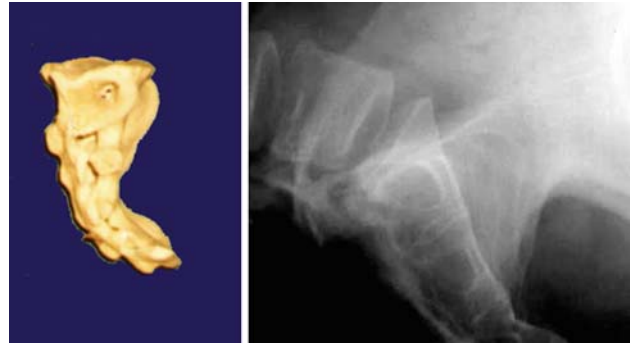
Synthetic bone model and the lateral sacral X-ray clearly show an oval area, the so-called “safety zone,” which is at the level of the first sacral peduncle.
